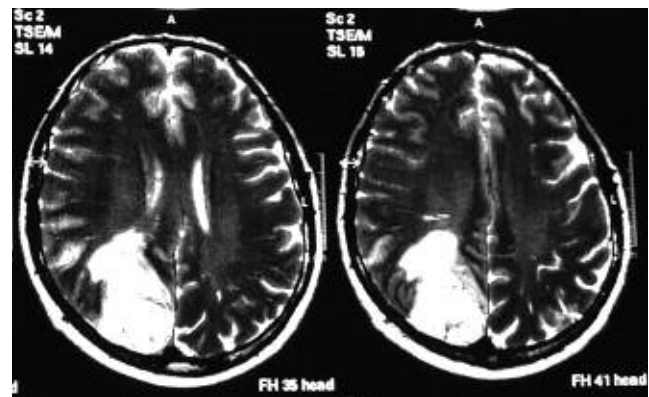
T2-weighted axial MRI sequences showing the glioblastoma multiforme in the right occipital lobe before the surgical operation.
